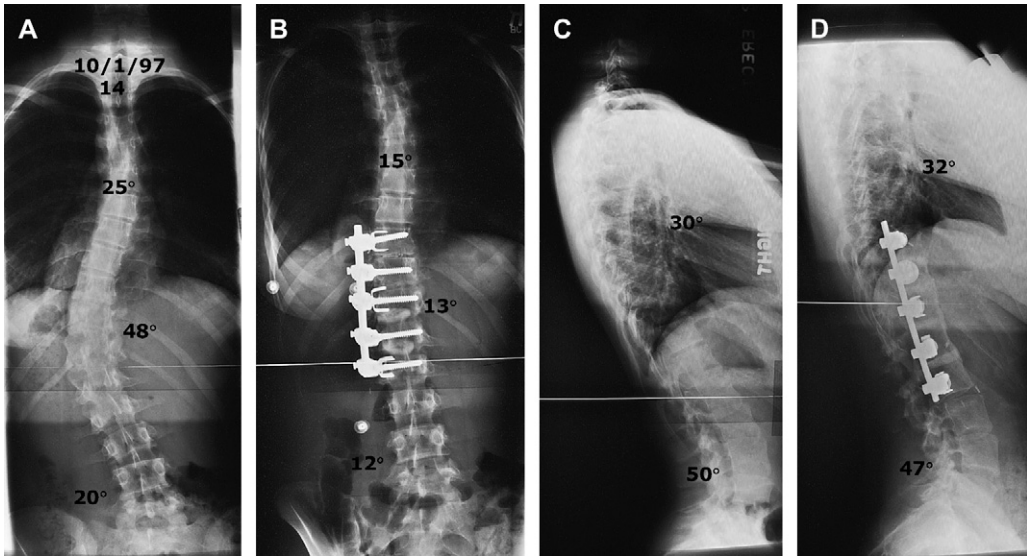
Preoperative (A, C) and postoperative (B, D) radiographs of a 14-year-old girl with an adolescent thoracolumbar scoliosis treated with anterior instrumented fusion.
